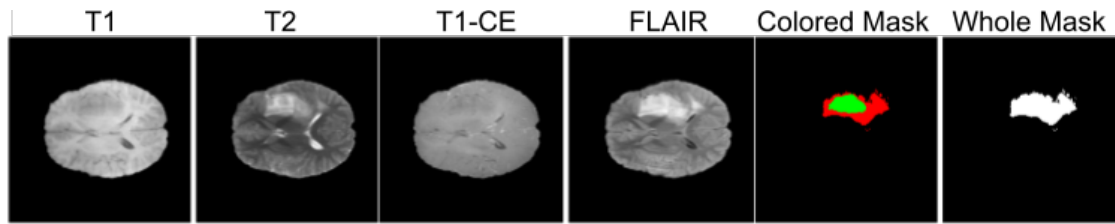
Sample from BraTS 2021 showing all four MRI modalities (T1, T2, T1CE, FLAIR), the colored multi-label mask, and its binarized whole tumor counterpart.
